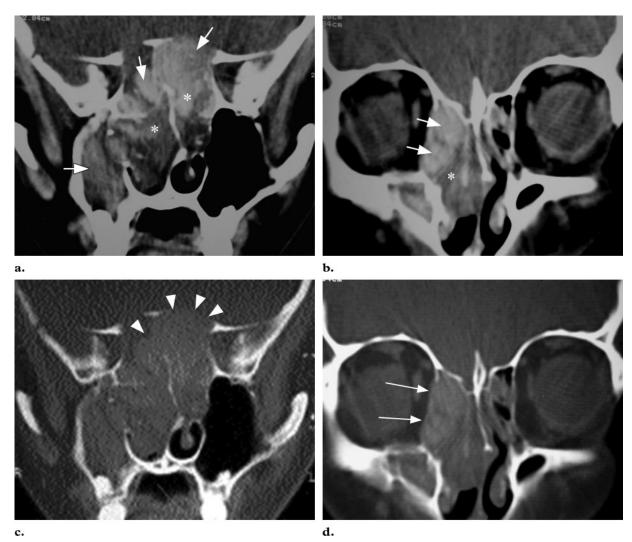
Allergic fungal sinusitis due to *Bipolaris* in a 26-year-old man. (a, b) Coronal CT scans (a obtained posterior to b) show characteristic expansile, hyperattenuating material in the sphenoid, ethmoid, and right maxillary sinuses (arrows). Extension into the nasal cavity (*) from the bilateral ethmoid sinuses and right maxillary sinus is noted. (c, d) Corresponding images obtained with bone windows show smooth erosion of the roofs of the posterior ethmoid sinuses (arrowheads in c) with intracranial extension, which is possibly limited by the dura. There is also smooth erosion of the medial wall of the right orbit (arrows in d) with intraorbital extension, which is possibly limited by the periosteum.
